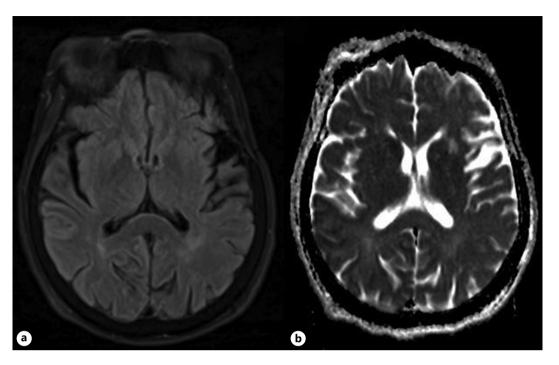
Case 1: a Axial T2-weighted Fluid attenuated inversion recovery (FLAIR) image. It is showing slightly high signal intensity (red flag) in the caudate nucleus bilateral. b Axial MRI ADC (Apparent diffusion coefficient). Signal decrease in the bilateral caudate nucleus higher left.
